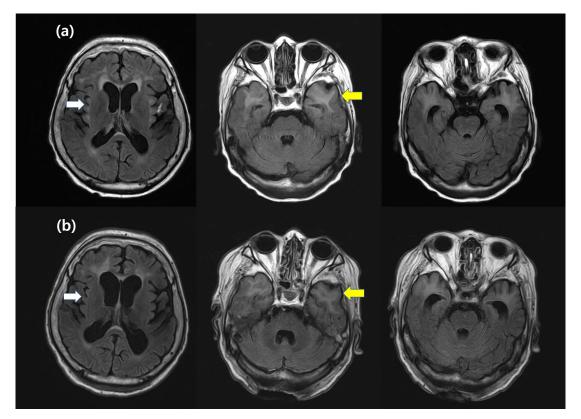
Brain FLAIR MRI showing diffuse brain atrophy and hyperintensity in the external capsule (white arrow) and the bilateral frontotemporal white matter (yellow arrow). (a) Initial evaluation of MRI, (b) Follow-up MRI after 6 months showing worsening of the brain atrophy
